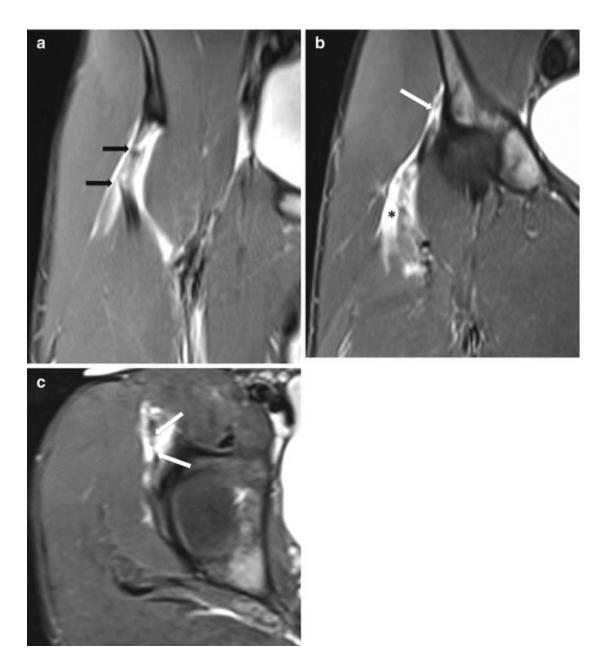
A 19-year-old male athlete with right partial tear of both direct and indirect heads of rectus femoris insertions. (a, b) Coronal fat-suppressed T2-weighted MRI show partial thickness discontinuity of the direct head close to the anterior inferior iliac spine (black arrows) and the indirect head at its attachment to superior acetabular ridge and the hip joint capsule (white arrow). Fluid collection surrounding the direct head is noted (asterisk). (c) Axial fat-suppressed T2-weighted MRI displays partial thickness tear of the indirect head (arrows)
